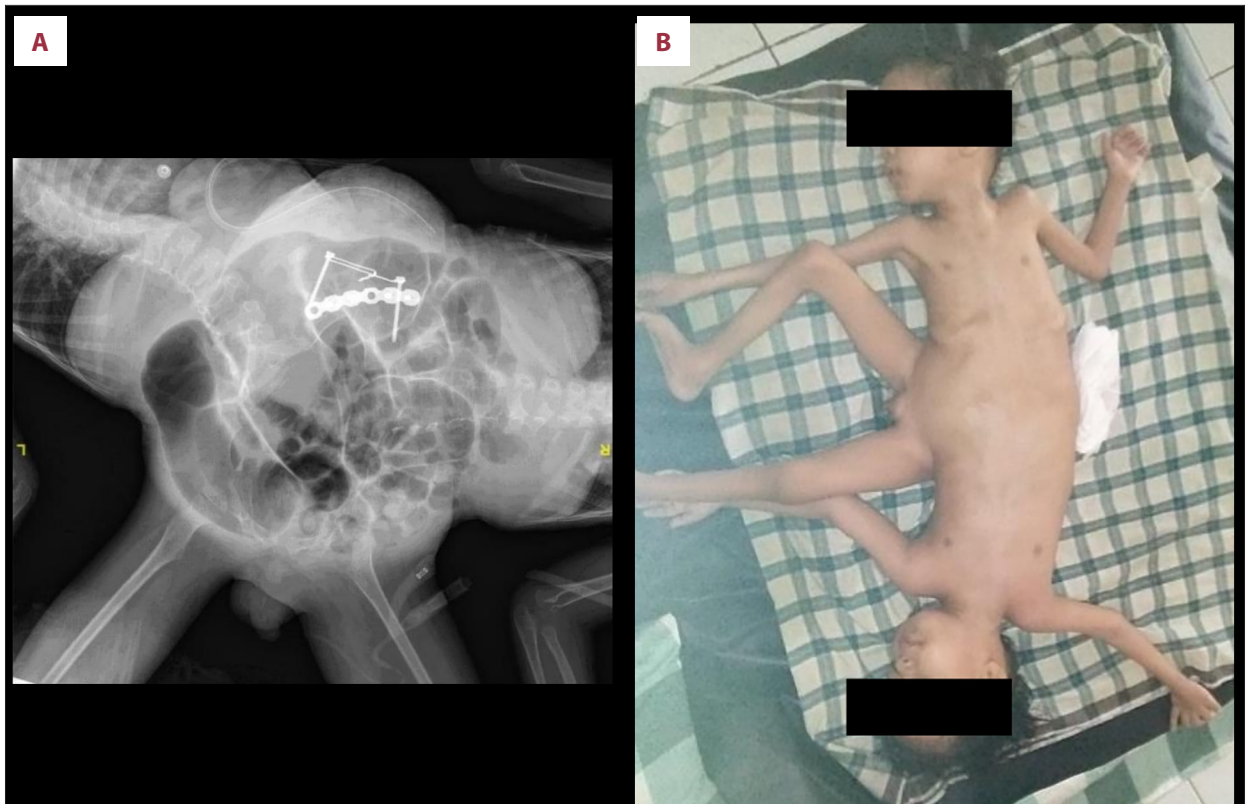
Postoperative (A) X-ray and (B) clinical condition.
